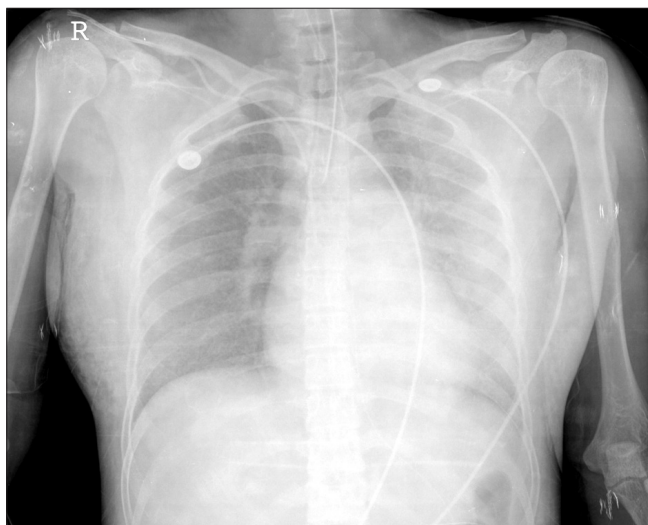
The plain chest radiography shows ground glass opacity and consolidation in both lung fields.
